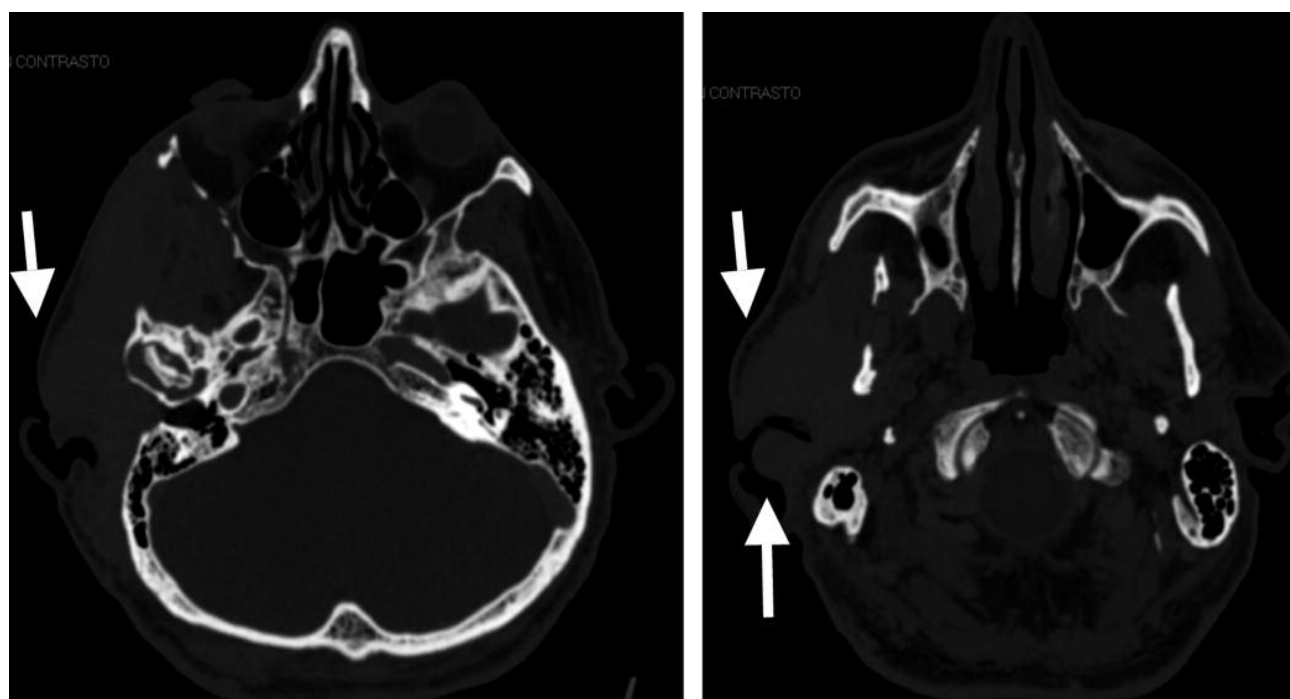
CT scans, axial sections: right temporal and parietal region mass causing obstruction of the right EAC (arrows).
